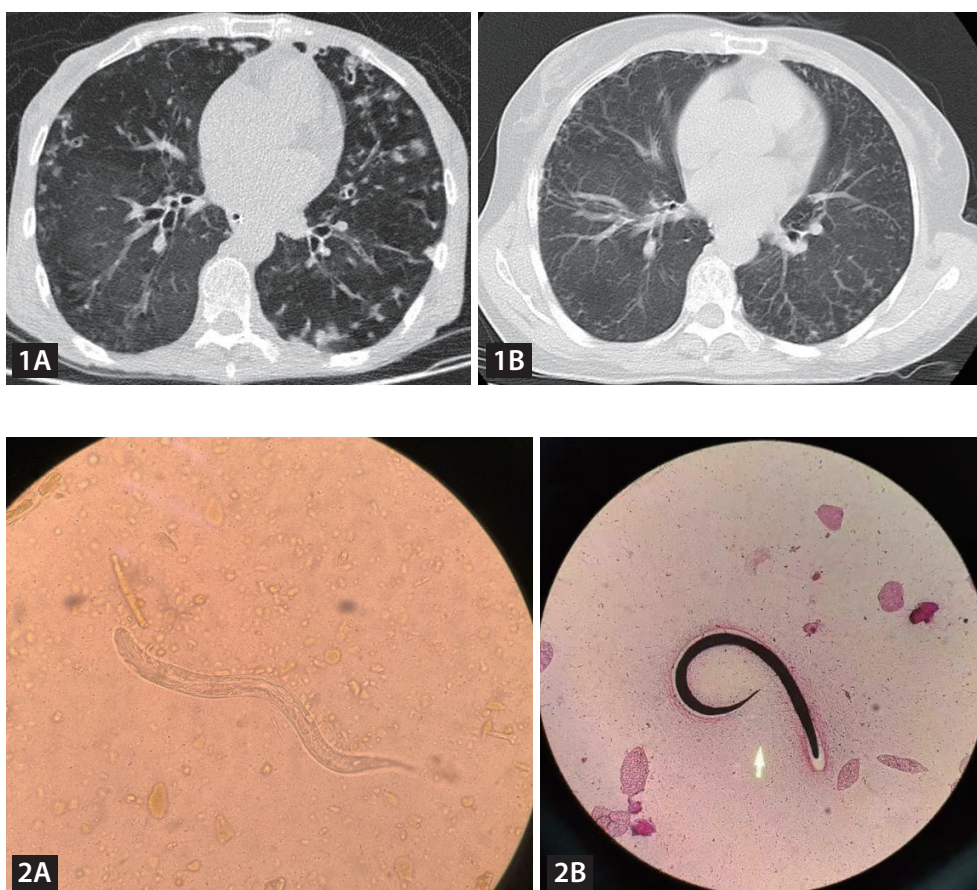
Chest computed tomography (CT) scan of the patient. (A) Chest CT indicated diffuse lung inflammation. (B) Follow-up chest CT scan showed significant improvement of the lesions.
